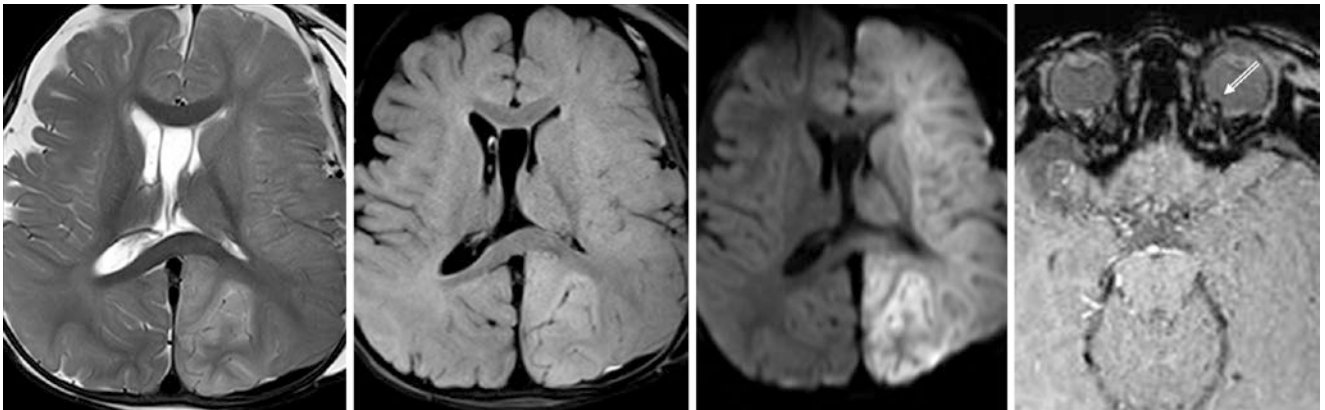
Comparison case of hypoxic-ischemic injury (HII) from abusive head trauma, i.e. non-accidental trauma (AHT, i.e. NAT). An 11-month-old had diffuse, but largely unilateral, cytototoxic edema on a 3T MRI with SE T2WI (*left*), FLAIR (*left middle*), and DWI (*right*
